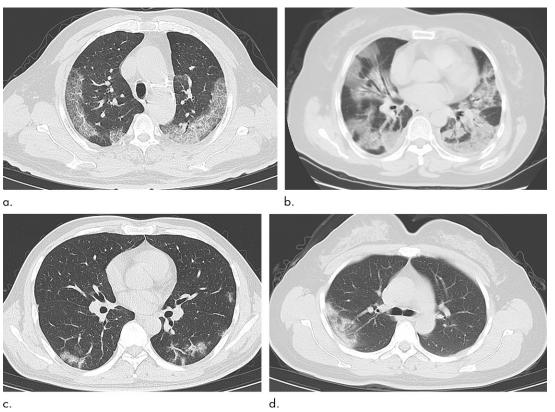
Examples of typical chest CT findings compatible with coronavirus disease 2019 (COVID-19) pneumonia in patients with epidemiologic and clinical presentation suspicious for COVID-19 infection. (a) Axial chest CT scan in 74-year-old man with fever and cough for 5 days shows bilateral subpleural ground-glass opacities. (b) Axial chest CT scan in 55-year-old woman with fever and cough for 7 days shows extensive bilateral ground-glass opacities and consolidation. (c) Axial chest CT scan in 43-yearold man who presented with fever and cough for 1 week shows small bilateral areas of peripheral ground-glass opacity with minimal consolidation. (d) Axial chest CT scan in 43-year-old woman who presented with fever with cough for 5 days shows a right lung region of peripheral consolidation.
